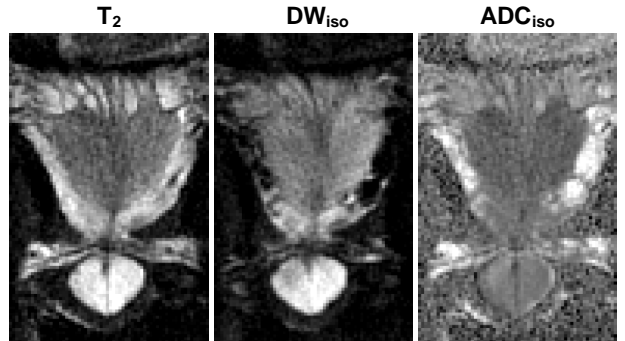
DWI of prostate: 7 coronal slices (only 1 shown here), $1.09 \times 1.09 \text{ mm}^2$ in-plane resolution, 5 mm slice thickness, 0.5 mm slice spacing, $14 \times 7 \text{ cm}^2$ FOV, readout in S/I direction, TE = 62 ms, b = 500 s/mm^2 , 6 min total scan time, using an 8-channel cardiac coil.
